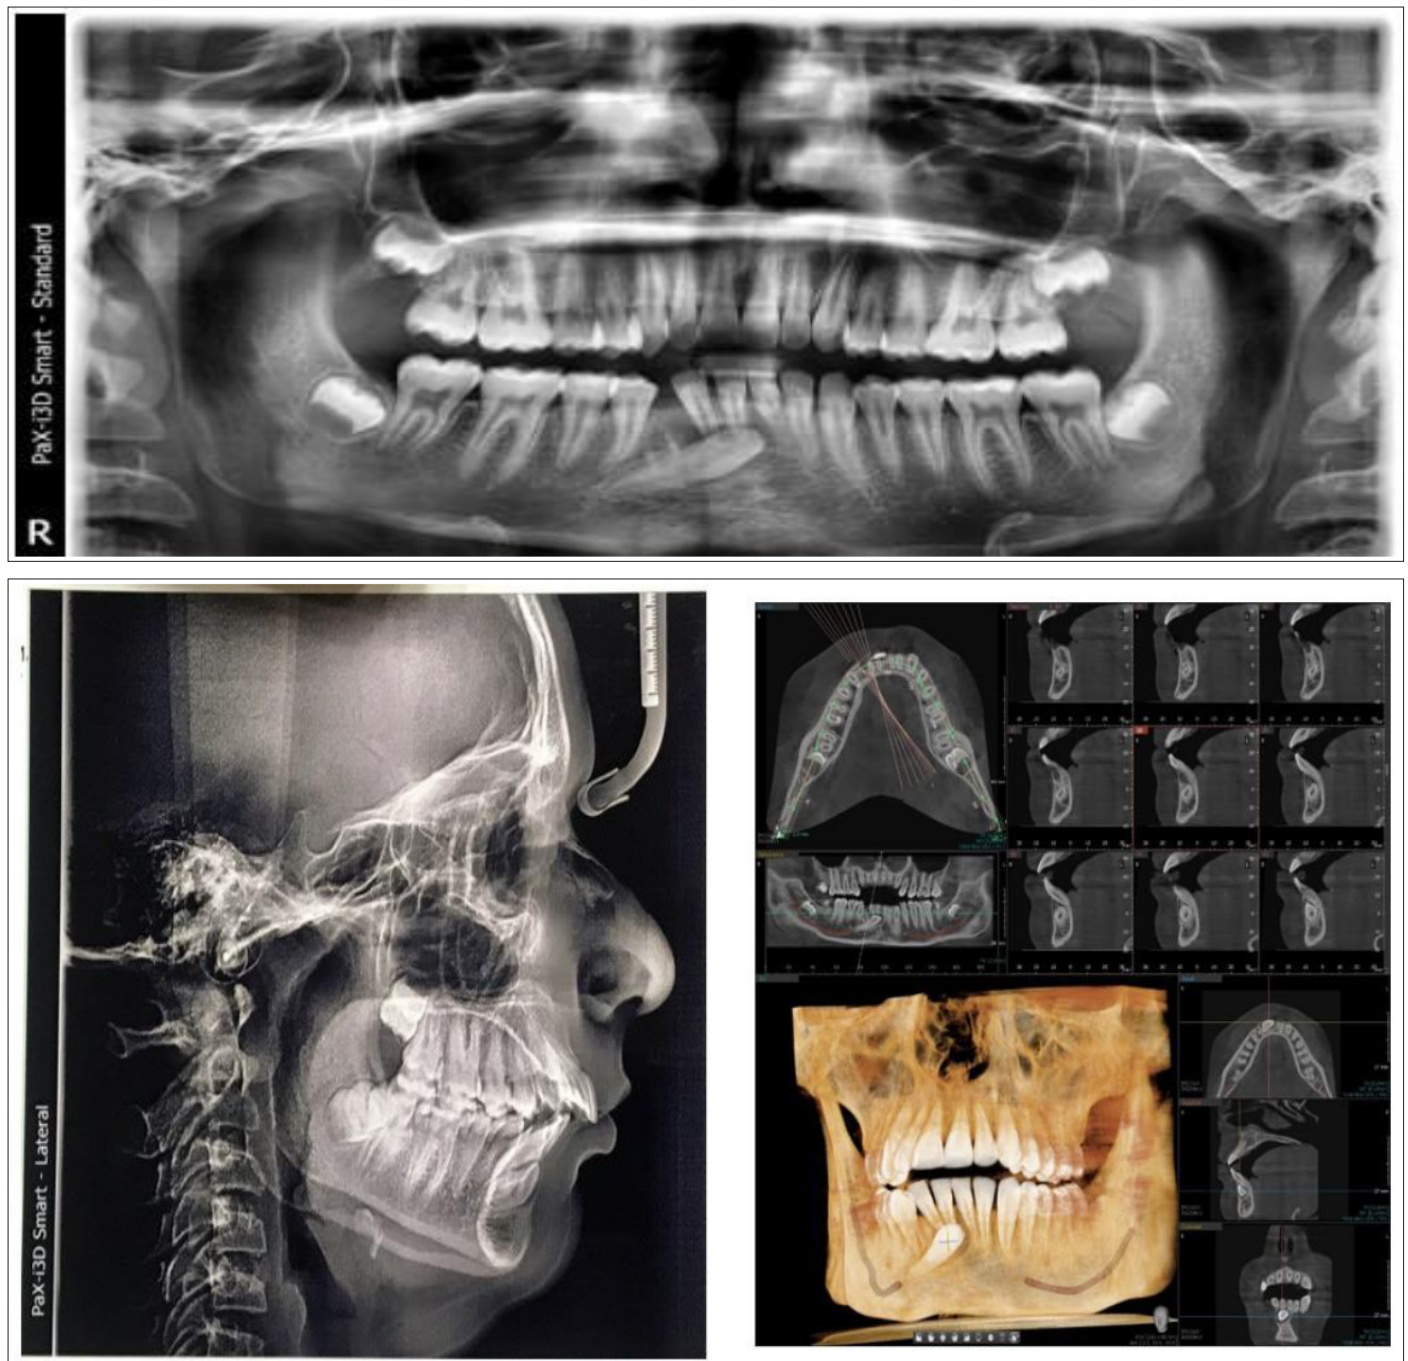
Pre-treatment panoramic X-ray(a), Lateral cephalometric(b) and CBCT(c)
